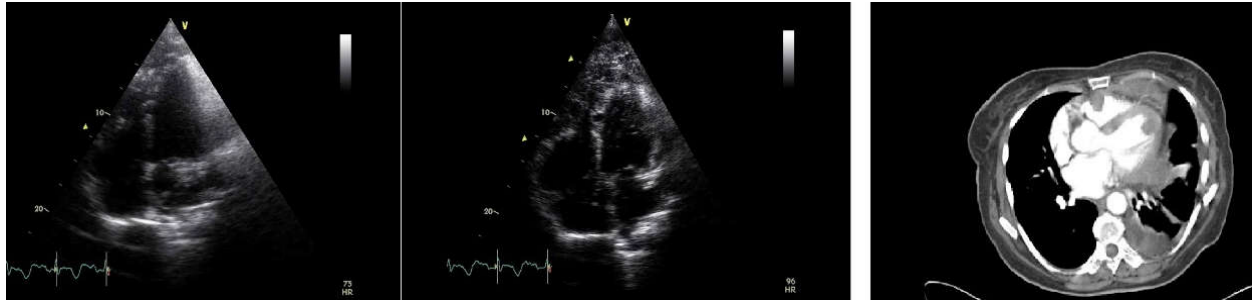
(a): Echocardiogram images (b) CT Chest (mediastinal window)
